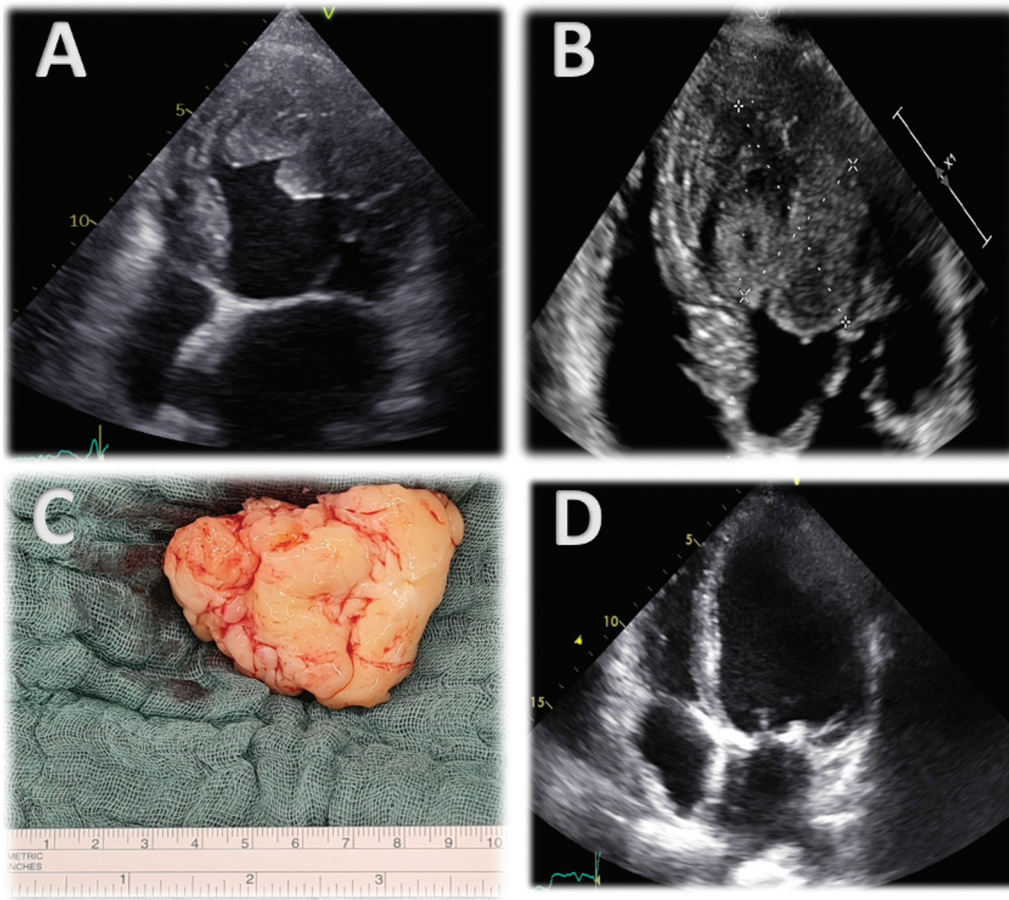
(A) Apical three-chamber view of transthoracic echocardiography at initial cardiovascular checkup with a suspicious 28 × 30mm echo dense mass in the left ventricle. (B) Cropped apical four-chamber view of transthoracic echocardiography 3 months later, showing inhomogeneous left ventricular apical mass (59 × 45 mm diameter), almost adherent to the mitral ring and irregular borders, occupying most of the ventricular cavity. (C) Intraoperative photograph after en-bloc resection of a huge whitish yellow tumor mass out of the left ventricle. (D) Apical four-chamber view of transthoracic echocardiography 2 years after minimally-invasive extraction of the sarcoma showing no recurrence or rather progression.
